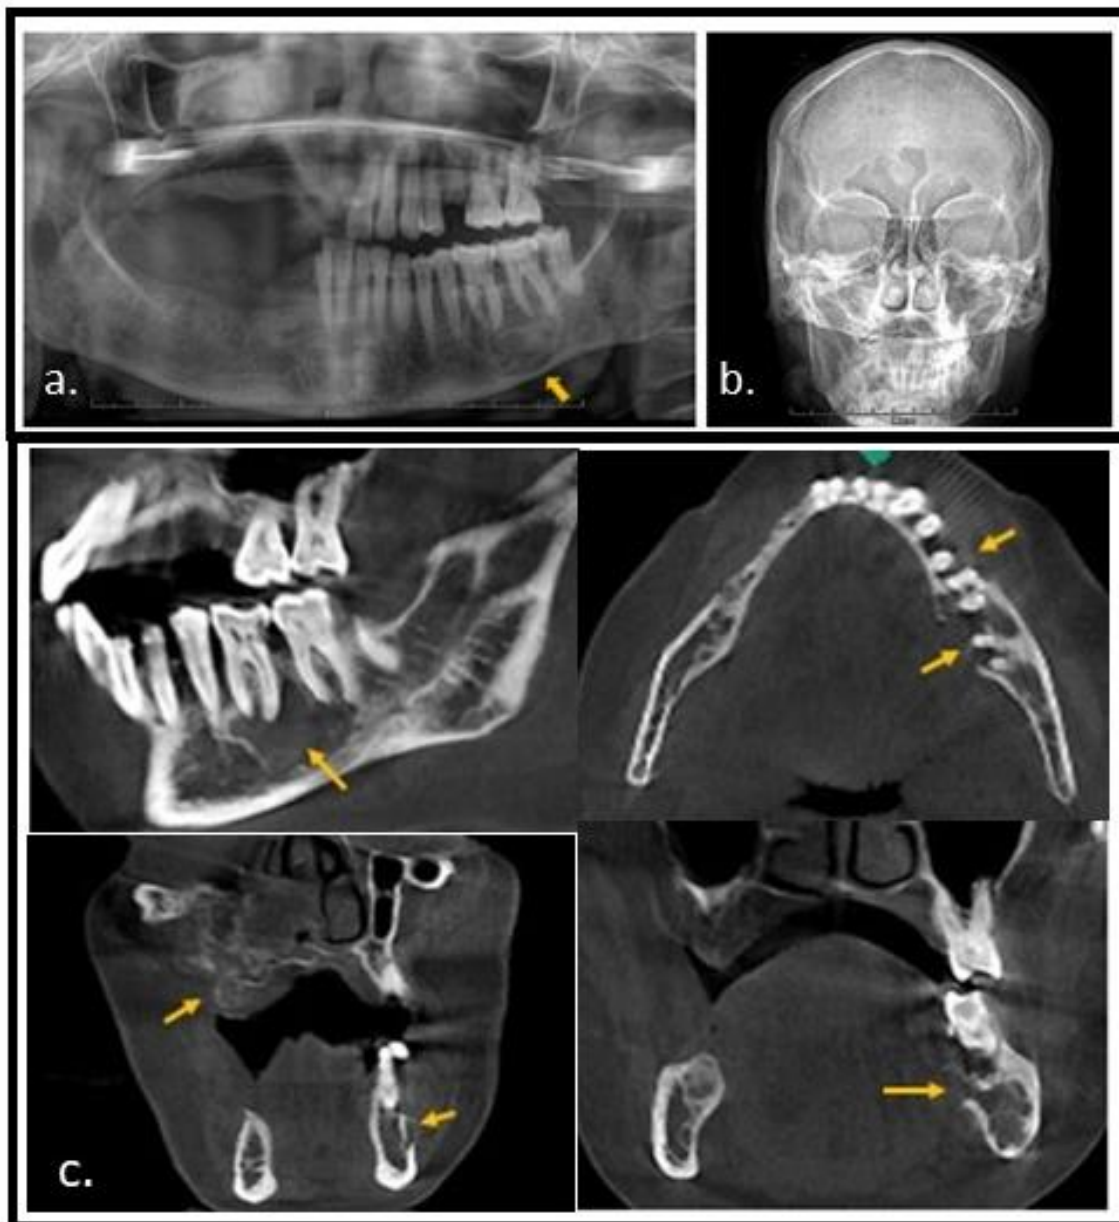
a. Orthopantomogram, b. PA skull, c. Sagittal, Axial and Coronal section of CBCT showing the lesion in the maxilla and mandible
